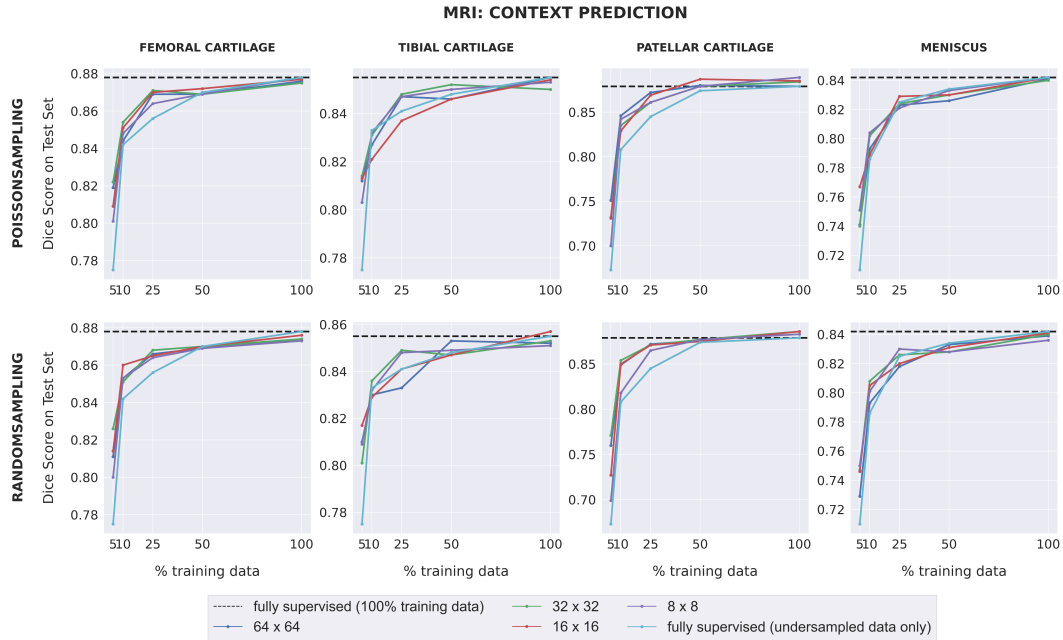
The downstream segmentation performance on the MRI dataset for the Context Prediction pretext task as measured by the Dice score for every combination of patch size and sampling method used during pretraining, evaluated in five different scenarios of training data availability. In each scenario, every model is trained for segmentation using one of the five different subsets of training data as described in Section 2.1.1. The black dotted line in each plot indicates the performance of a fully supervised model trained using all available training images. The light blue curve indicates the performance of a fully supervised model when trained using each of the five different subsets of training data.
